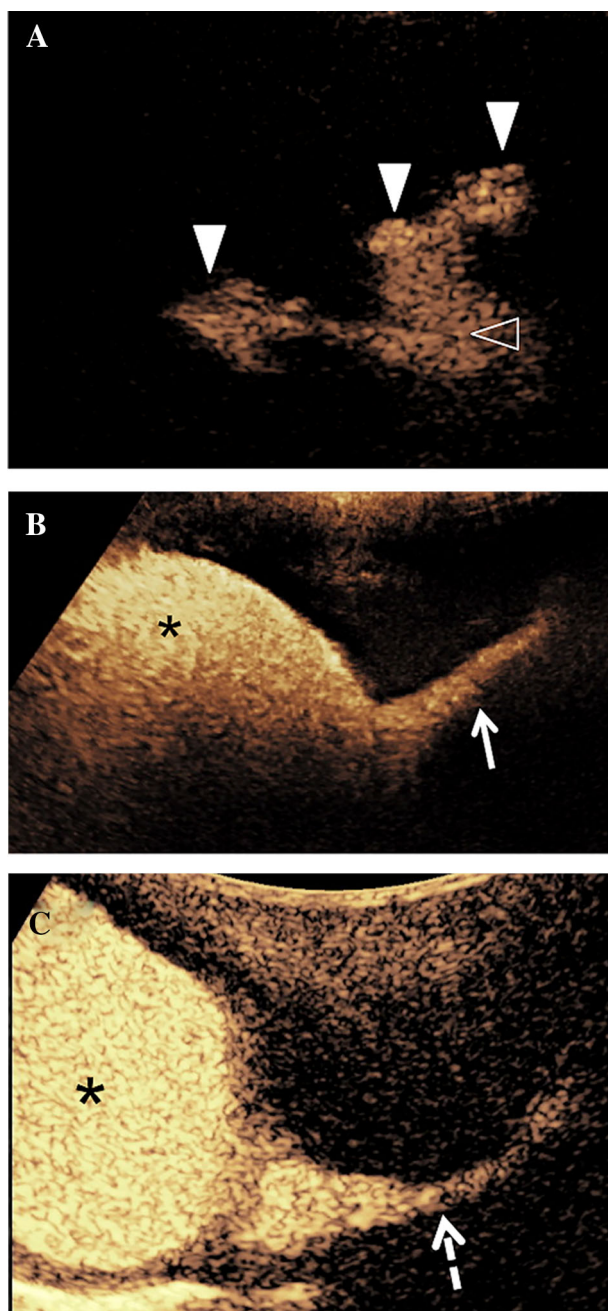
Contrast-enhanced voiding urosonography. A, B 6.3-year-old girl referred for follow-up of previously known vesicoureteral reflux. Echogenic microbubbles are seen in the pelvis (open arrowhead) and calyces (solid arrowheads) of the right kidney which are mildly dilated in keeping with Grade 2 reflux. B Urinary bladder (asterisk) is filled with echogenic microbubbles. The proximal segment of the female urethra (arrow) is delineated during the beginning of the voiding phase and has normal morphology. C Different male patient. Urinary bladder (asterisk) is filled with echogenic microbubbles. The male urethra (dashed arrow) is delineated throughout its course during voiding phase with no evidence of intraluminal pathology.
